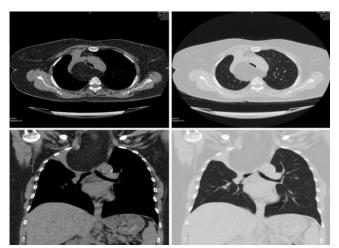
Thorax CT image of the patient at the time of diagnosis in which a sharply demarcated, lobulated contour, hypodense mass lesion compatible with lipoma can be seen in the retroesophageal area in the posterior mediastinum, starting from the carina level below and extending to the neck level above, deviating the trachea and esophagus anteriorly
